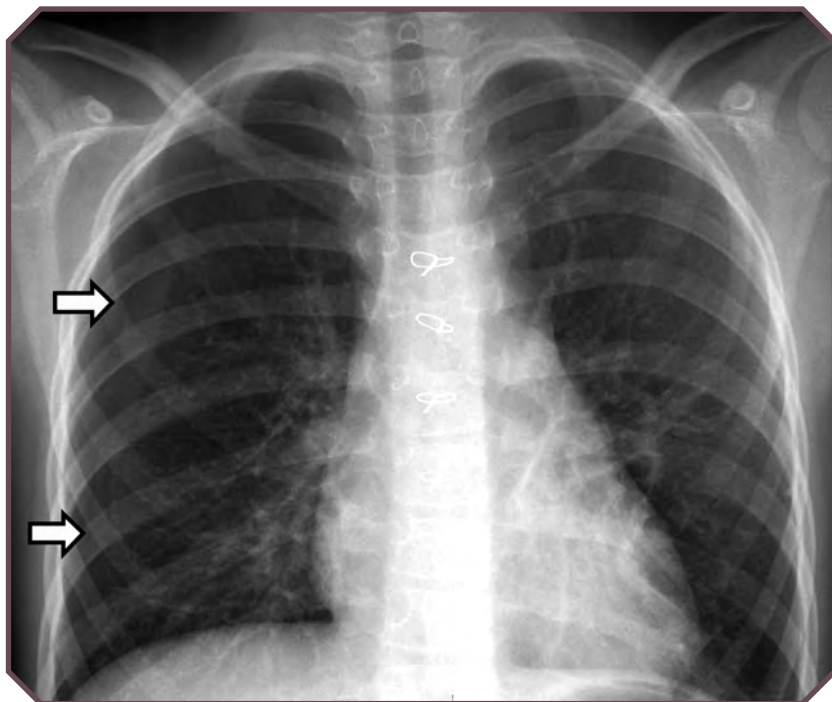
Pneumothorax in a 7-year-old girl with chest pain and shortness of breath. Frontal chest radiograph shows a right pleural line (arrows) that indicates a pneumothorax. Due to recurrence, surgery was performed and demonstrated that the pneumothorax was caused by an apical bleb.
